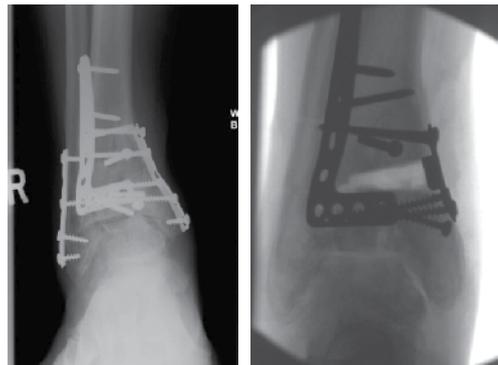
Radiographic images of a medial opening wedge osteotomy after open reduction and internal fixation resulted in a varus malunion. The distal screws were removed from the original plate and an opening wedge osteotomy was performed using an interposition plate.
